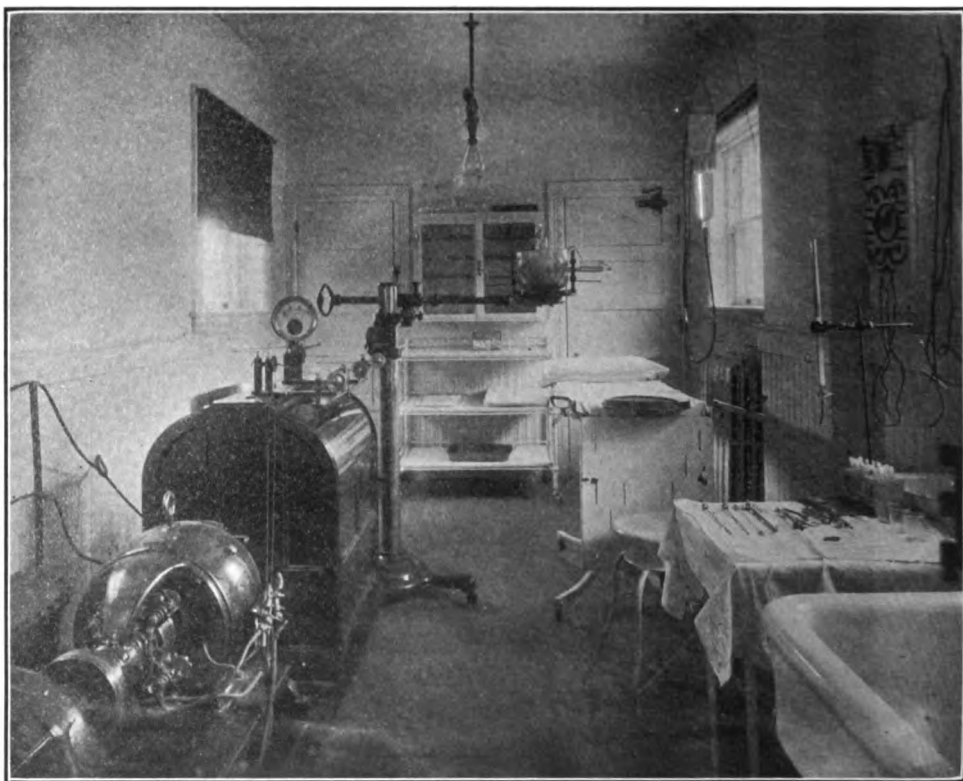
Diagnostic room fitted up for combined use of cystoscope and X-ray. On the right, test tube rack with sterile 5 c.c. tubes for collecting urine from ureteral catheters; also burette for injecting collargol solution.
